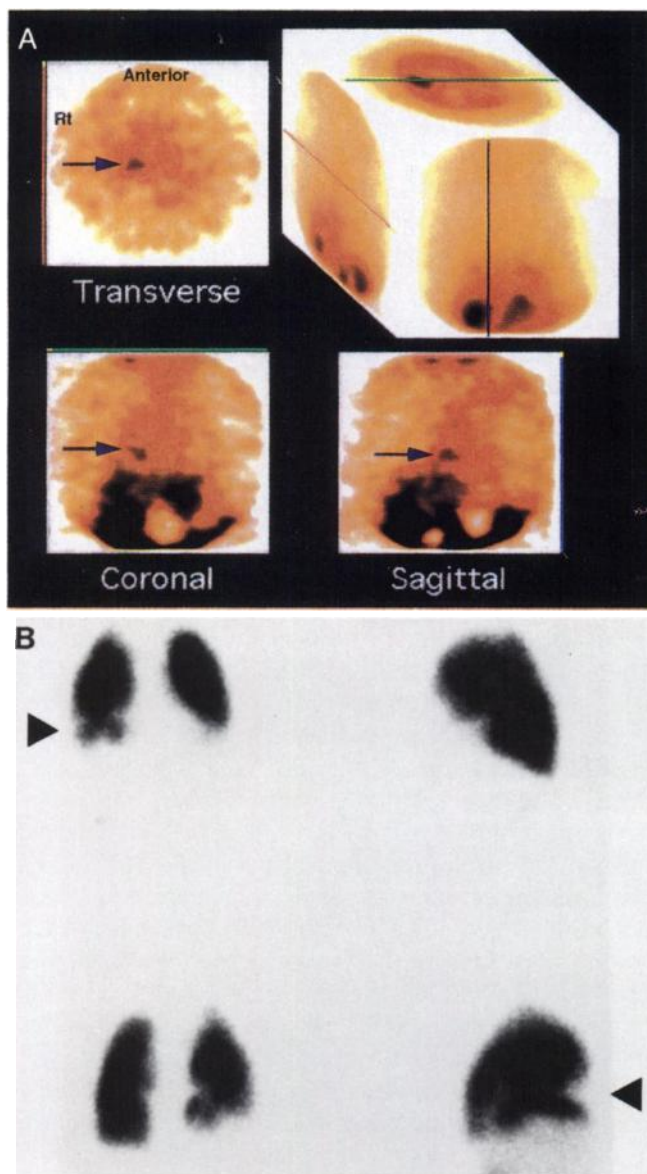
(A) SPECT reconstructions performed 2 hr postinjection detected a small pulmonary embolus in the lower lobe of the right lung (arrows). (B) Anterior, left lateral, right lateral and posterior planar views of the lung perfusion scan, in which a photopenic area is evident in the same pulmonary segment as the focus of ^{99m}Tc -P280. Pulmonary angiography results also corroborated the peptide study results.
